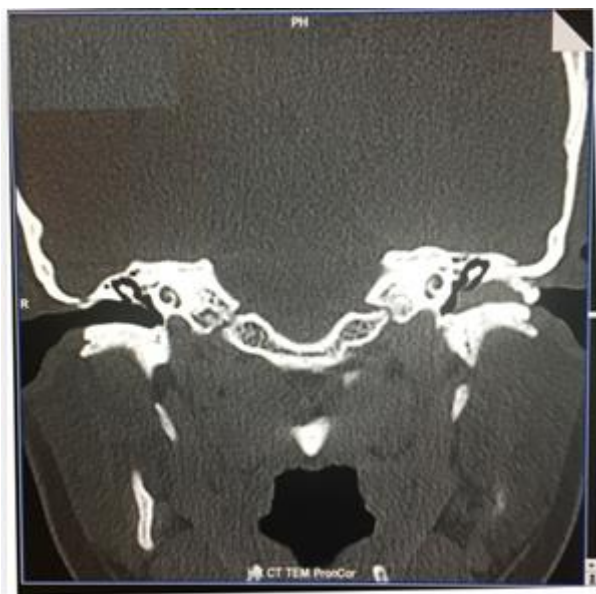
CT – Temporal Bone
